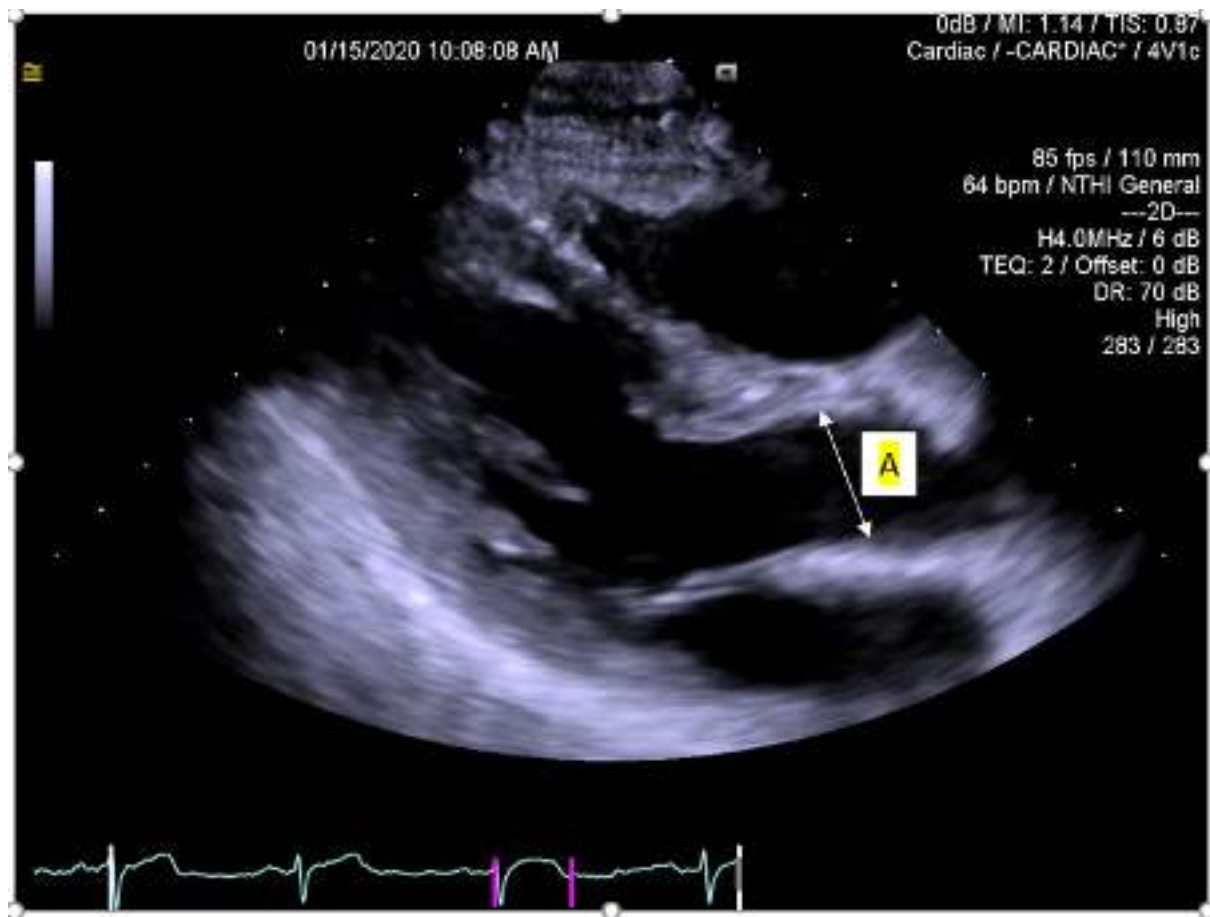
Aortic diameter measurements obtained just beyond the aortic root at the tip of the aortic valves when in the open position in the outflow tract in the parasternal long axis view. A is Aortic root diameter in systole.
